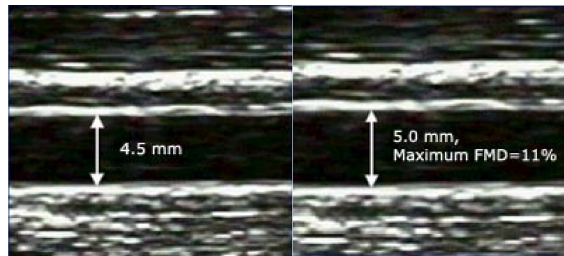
Measurement of brachial artery flow-mediated dilation (FMD) by ultrasound. Brachial artery diameter at rest (left) and after cuff release (right).
